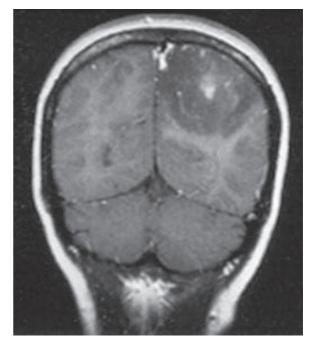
Contrast-enhanced T1-weighted MRI of an anaplastic astrocytoma (*AA*). A low attenuation lesion with minimal enhancement on T1-weighted MRI with minimal to moderate edema on T2-weighted MRI is suggestive of AA (printed from [1] with permission)
